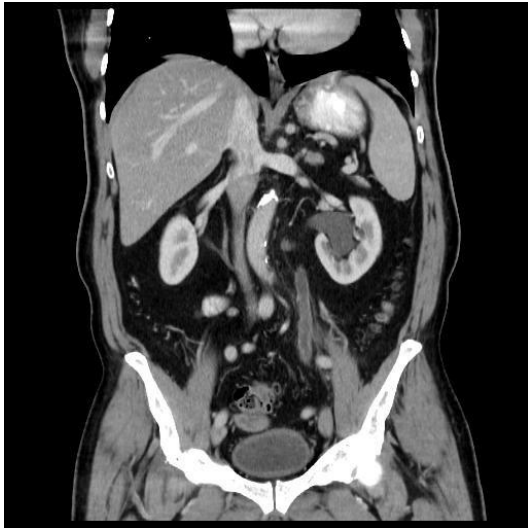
A Contrast CT Showing Left Dilated Renal Pelvis and Ureter
